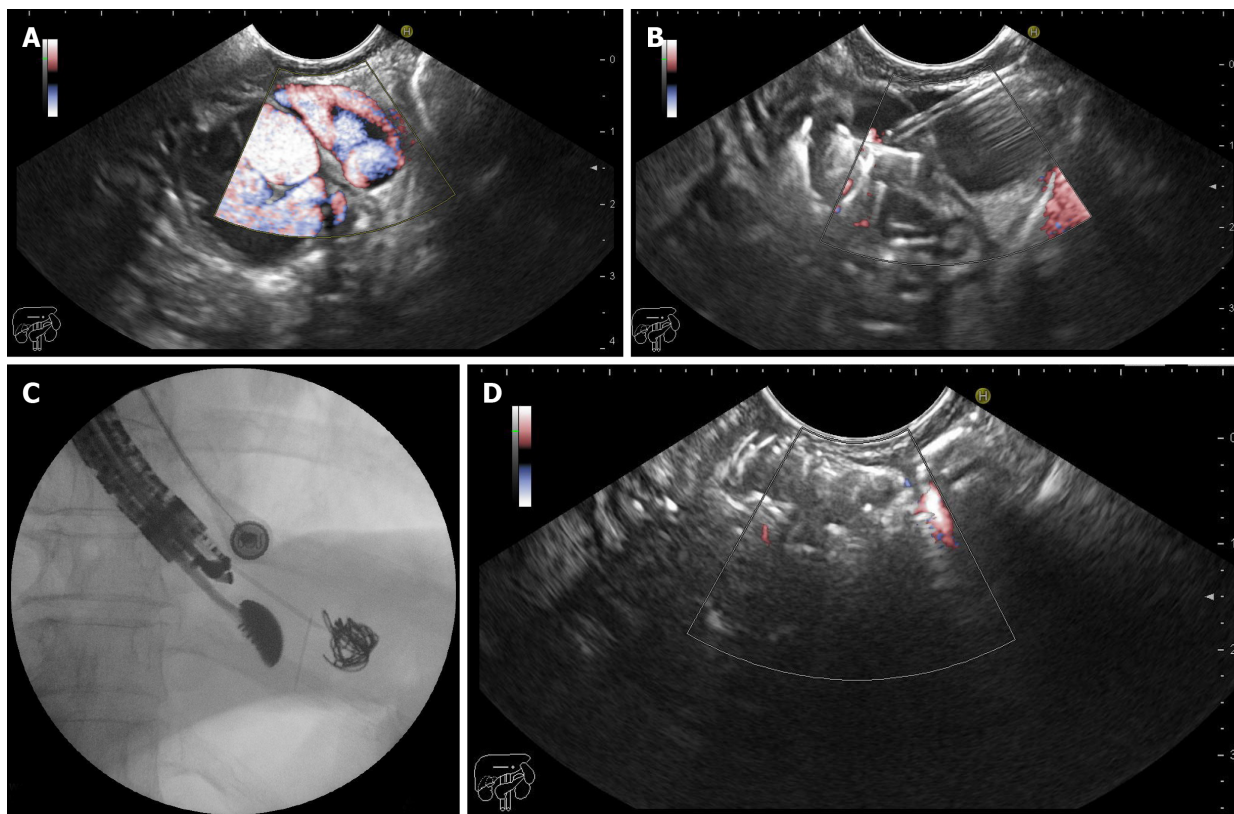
Endoscopic ultrasound-guided coiling plus cyanoacrylate injection for the management of gastric varices. A: Endoscopic ultrasound (EUS)-Doppler evaluation of the gastric varix feeder vessel; B: EUS-guided fine-needle puncture and cyanoacrylate injection; C: Fluoroscopic view of EUS-guided coiling of gastric varices; D: EUS-Doppler demonstrating absence of flow after combined therapy.
